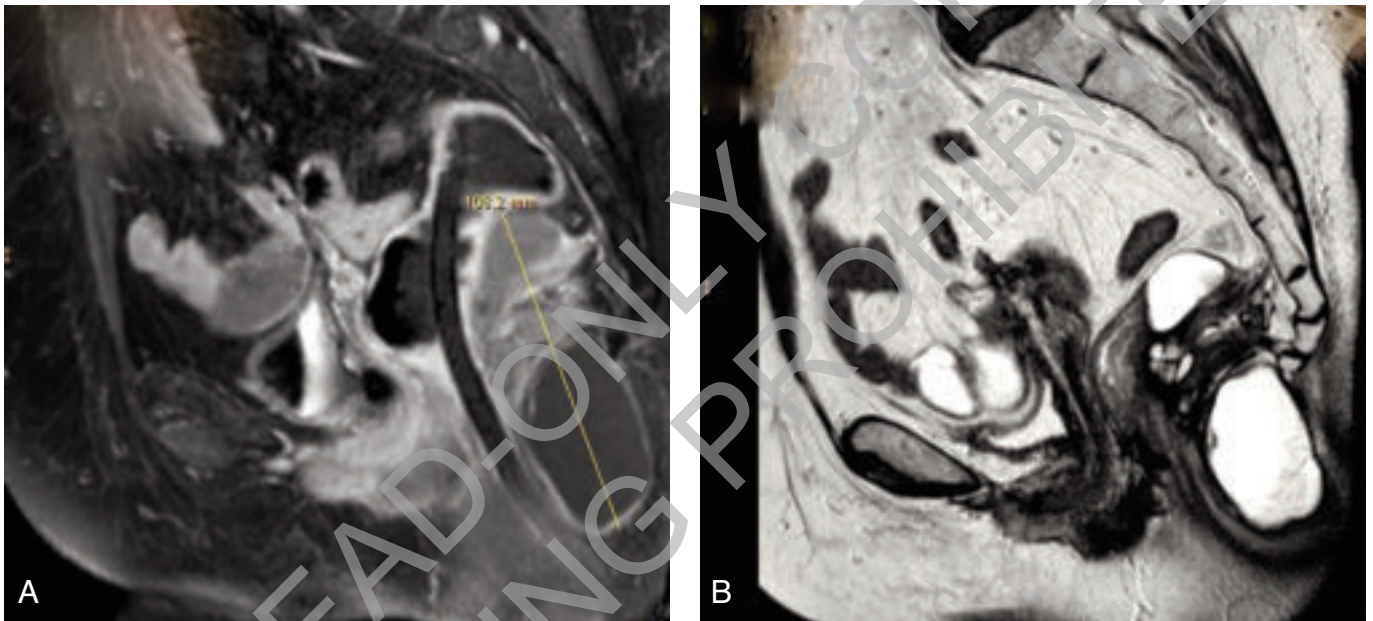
(A) T1- and T2-weighted (B) magnetic resonance images. T1-weighted sagittal MRI scan showing the retrorectal multiloculated cyst and the rectum (rectal tube).
